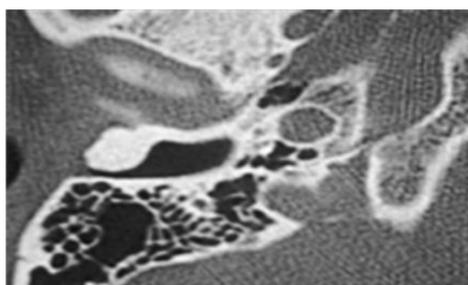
Axial cut CT scan of the right temporal showing a more dense osteoma involving the lateral aspect of the external auditory canal and causing significant narrowing
